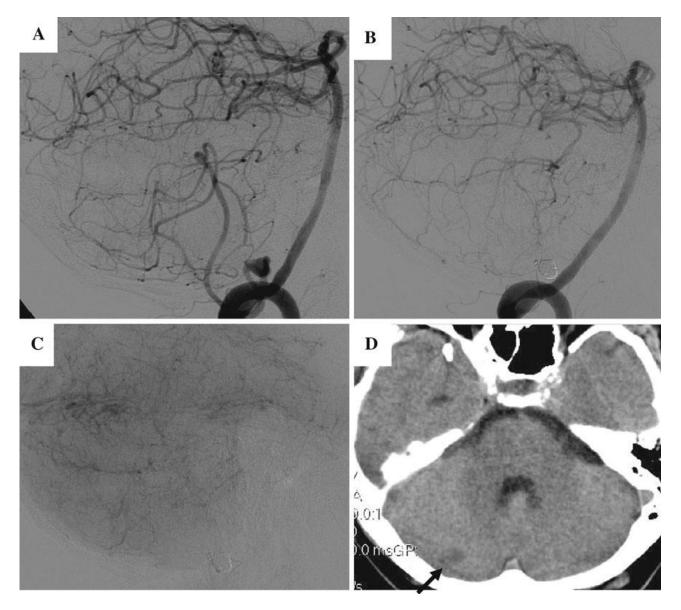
In this patient the large neck tonsillomedullary PICA aneurysm was occluded together with its parent vessel by endovascular coiling (a, b). Adequate leptomeningeal collaterals from the SCA and the AICA provide for a good filling of the PICA territory in the arteriolar phase at control angiography (c). A small ischemic lesion can be observed at CT scan (d) that remained completely asymptomatic
